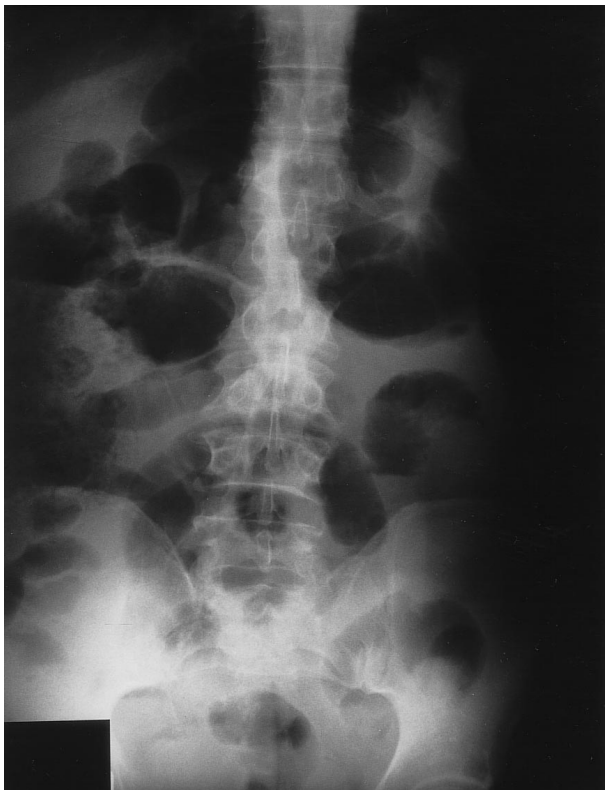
Abdominal plain radiograph in stand-up position 3 days after ESWL. Large bowel distension, air-fluid levels in the small bowel and air in the rectum are present.
